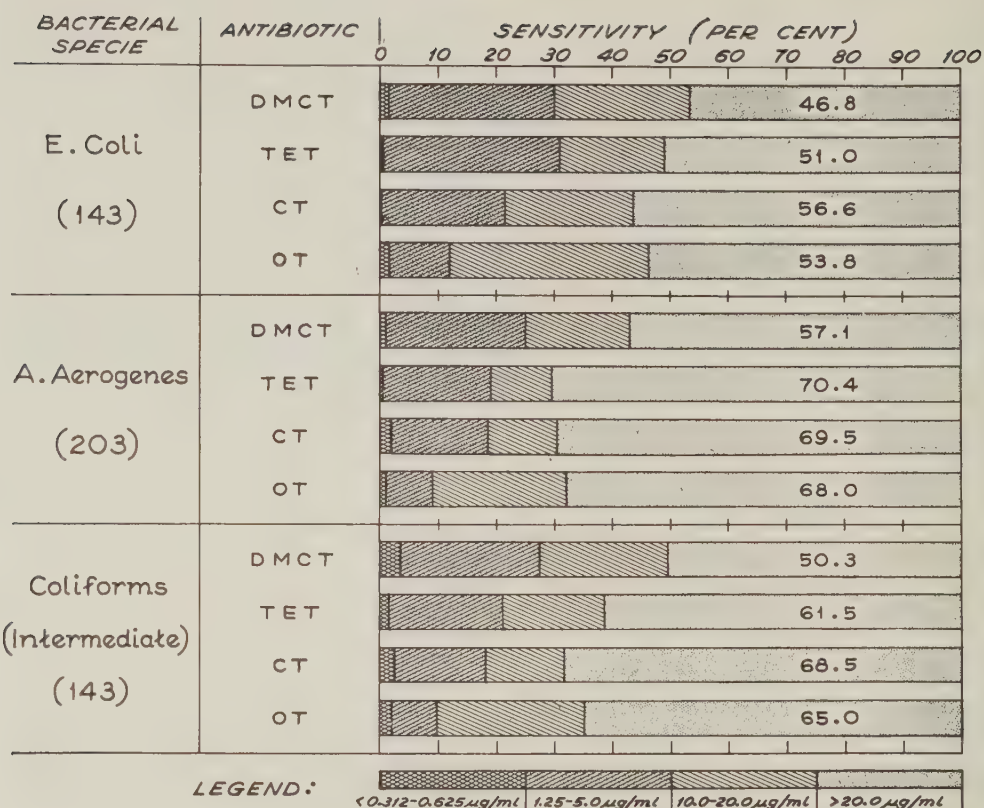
Comparative sensitivity of bacteria to tetracycline analogues. DMCT = demethylchlortetracycline; TET = tetracycline; CT = chlortetracycline; OT = oxytetracycline.
